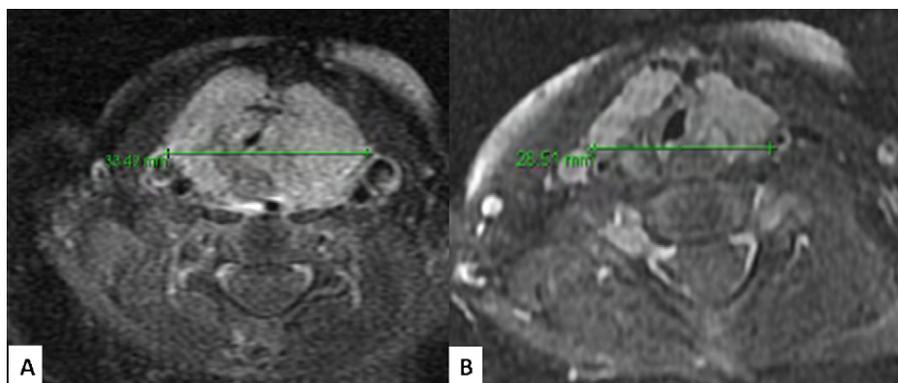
Patient 6 axial imaging MRI at the level of the subglottis. Before propranolol therapy, hemangioma noted extending from subglottis to a circumferential lesion involving the thyroid gland, compressing the airway (A). After 1 week of propranolol therapy, significant improvement in subglottic airway and decreased size of circumferential extension (B).
